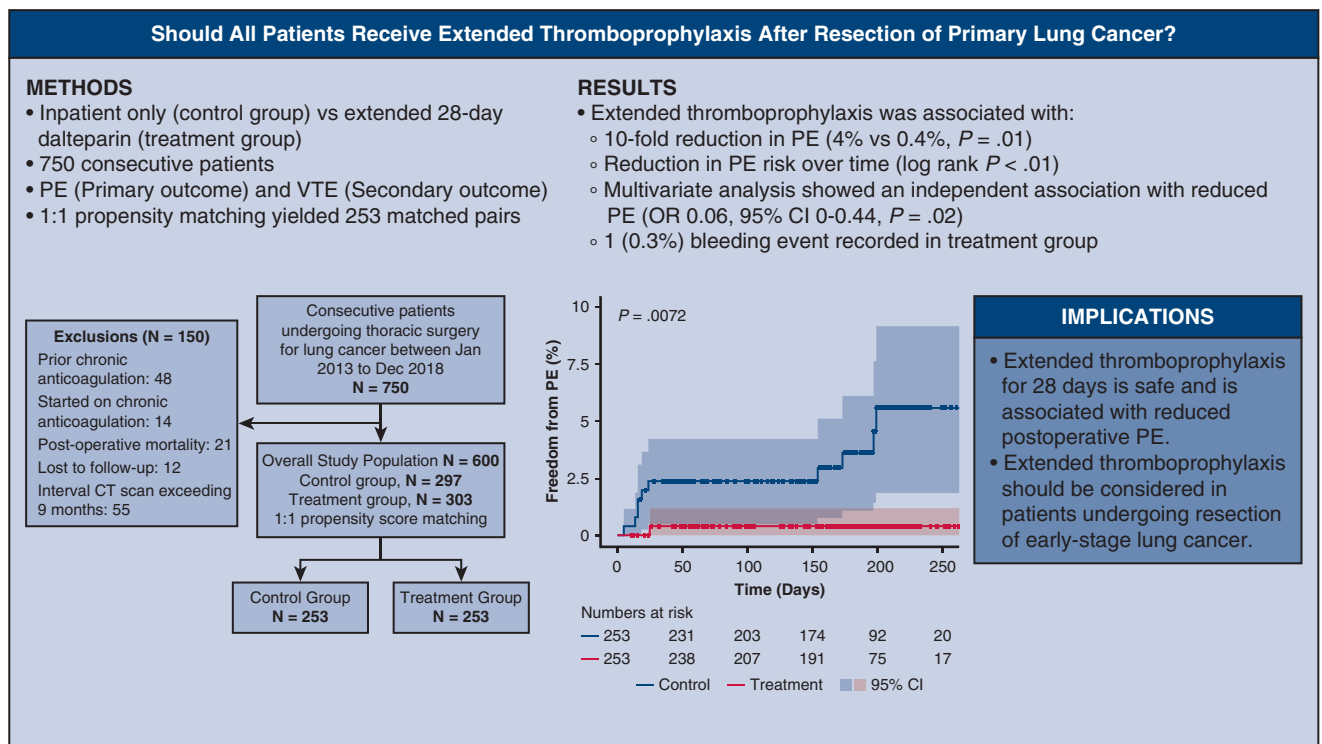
Thromboembolic outcomes according to short duration or extended duration thromboprophylaxis in patients who underwent resection of primary lung cancer. PE, Pulmonary embolism; VTE, venous thromboembolism; OR, odds ratio; CI, confidence interval; CT, computed tomography.
